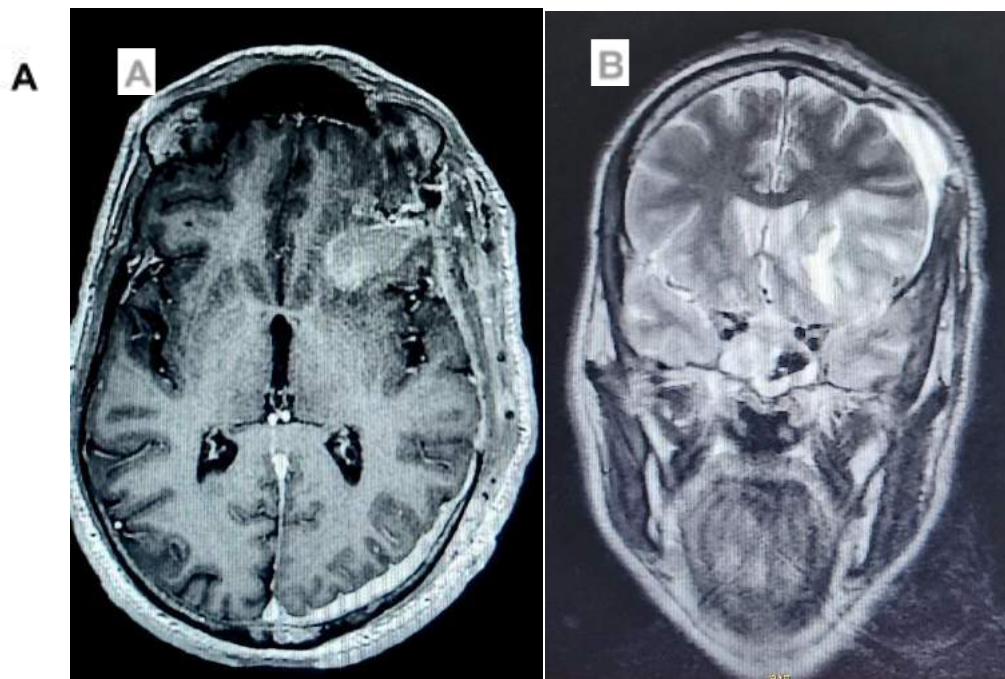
Head magnetic resonance imaging; A/ axial T1-Weighted, B/ coronal T2- Weighted with the left frontal ICH with the and the ASDH
